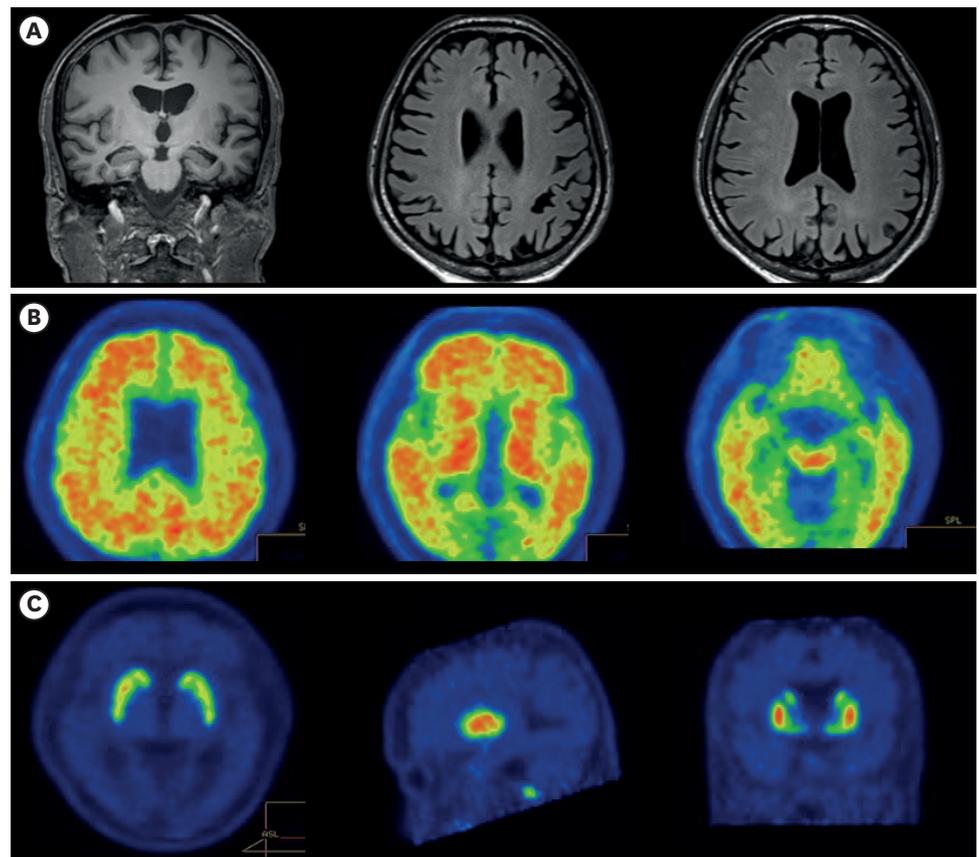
Neuroimaging of Patient 3. Brain magnetic resonance imaging (A) showed left frontoparietal atrophy, hippocampal atrophy score of 1 on the right and 2 on the left based on the Scheltens' scale¹¹ and grade 0 periventricular and grade 1 deep white matter hyperintensities based on the Fazekas scale.¹² F-18 Flutemetamol positron emission tomography computed tomography showed (B) abnormal accumulation of β -amyloid plaque in the frontal, temporoparietal cortex, and striatum. However, 18F FP-CIT positron emission tomography showed (C) normal FP-CIT uptakes in both basal ganglia on delayed phase.
